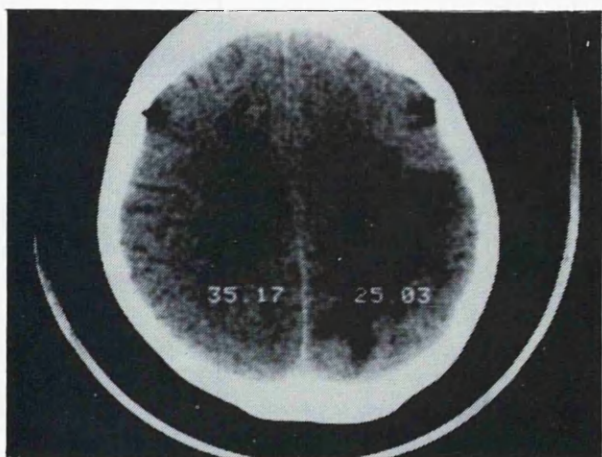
A 54 years old female with breast cancer under control, developed right sided weakness in the upper and lower limbs. CT scan showed a large lesion in the left hemisphere dif. diagnosis CVA or metastasis.
